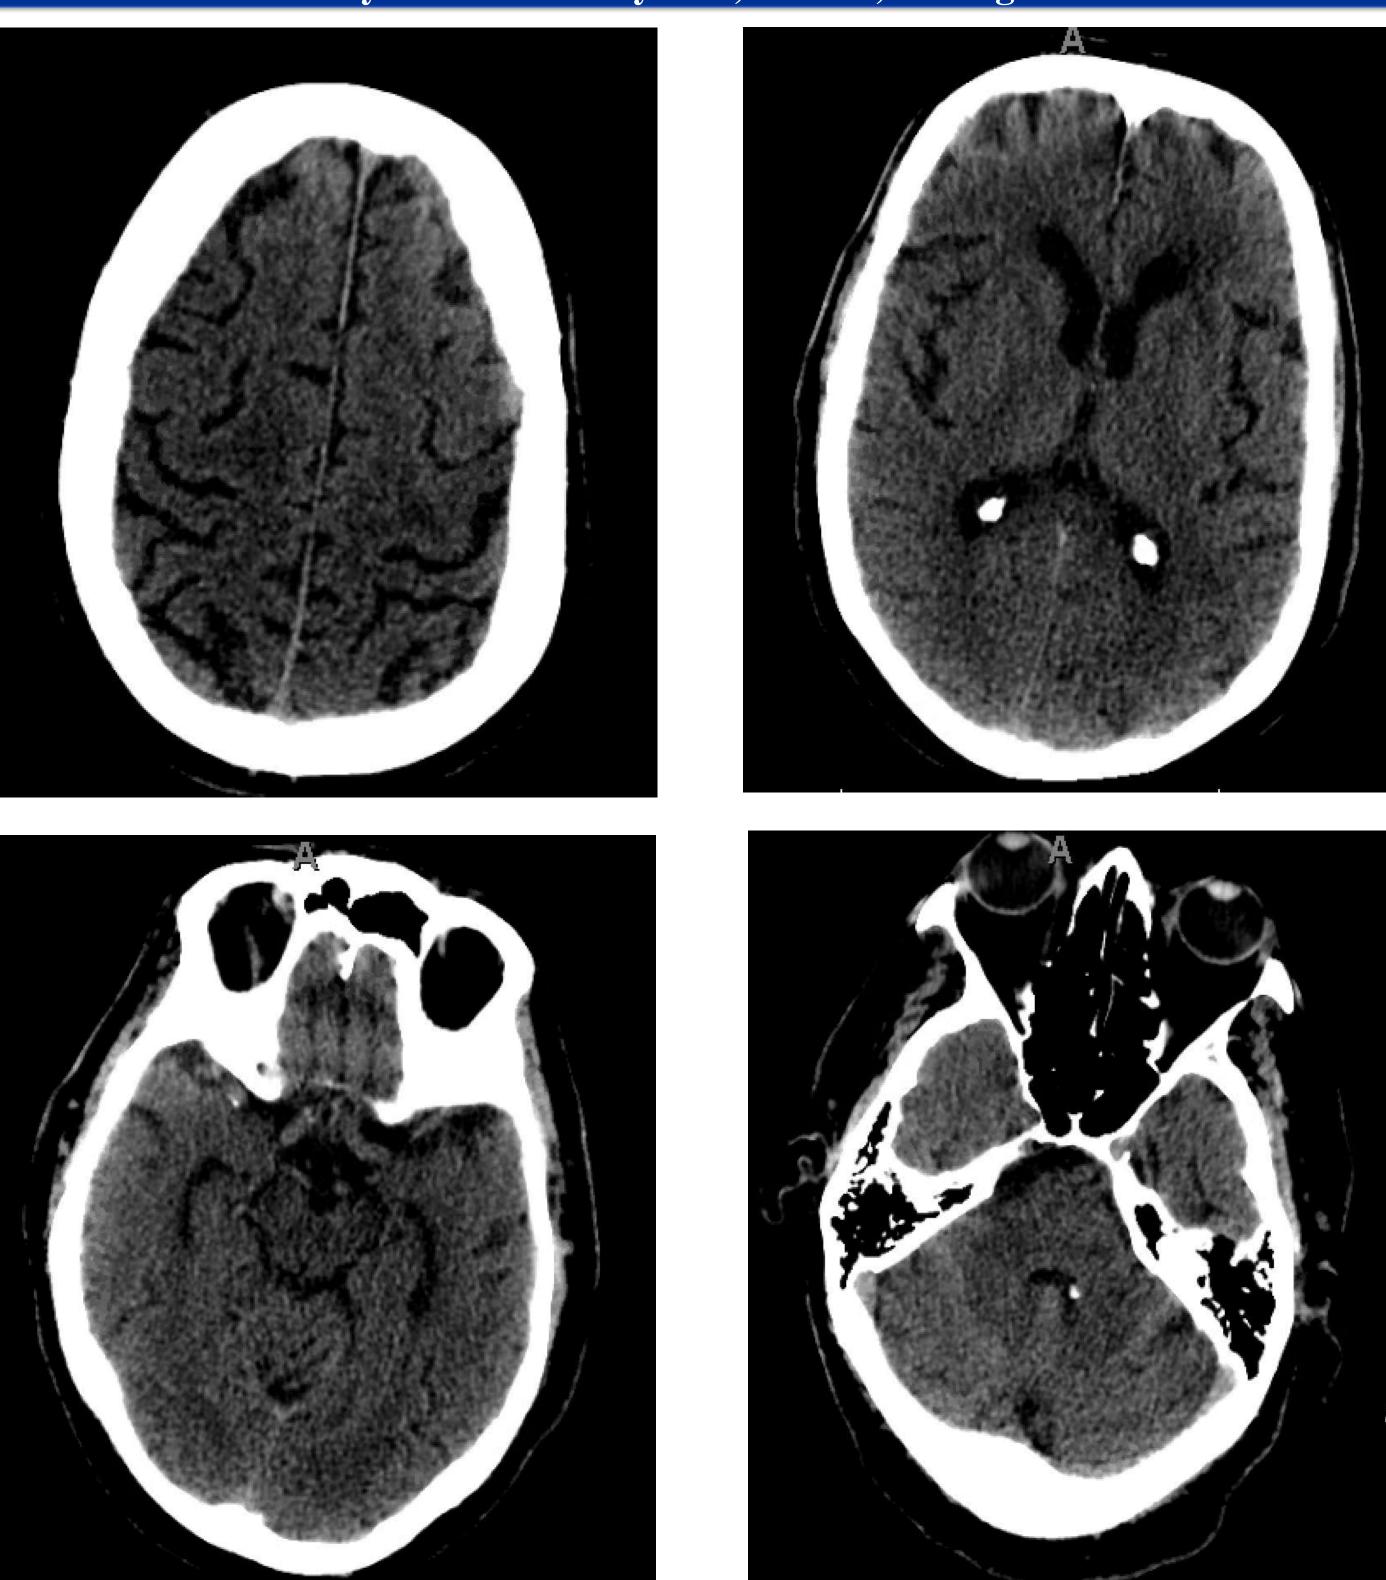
CT Scan of the head demonstrating no definite acute intracranial process
